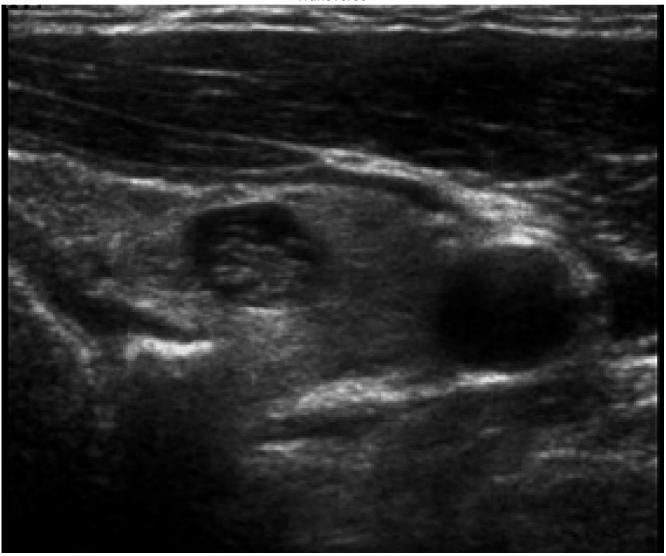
Ultrasound of a colloid nodule in the left lobe. Transverse, 7 x 10 mm.
